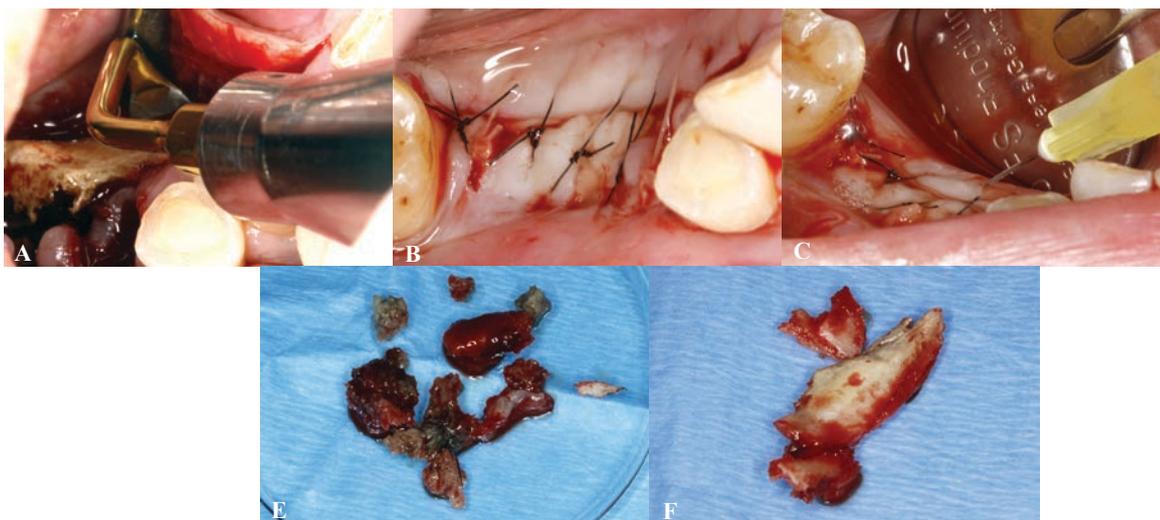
(A) Excision of necrotic bone with ultrasound surgery. (B) Primary closure of the surgical wound after the placement of Endoret (PRGF). (C) After this the incision margins were infiltrated with Endoret (PRGF) liquid (fraction 2 recently activated). (D) Soft tissue fragments that surrounded the bone sequestrum. (E) Bone fragments of necrotic tissue after the excision.
